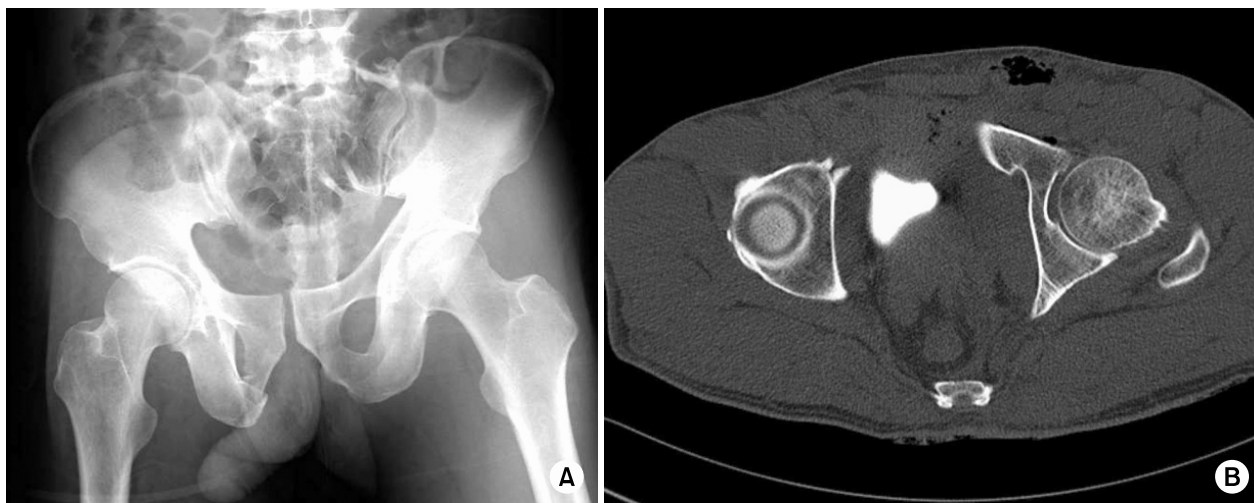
Post reduction pelvis AP radiograph and pelvis CT show concentric reduction of left femoral head (A, B). Concentric reduction was maintained by skeletal traction (A).
